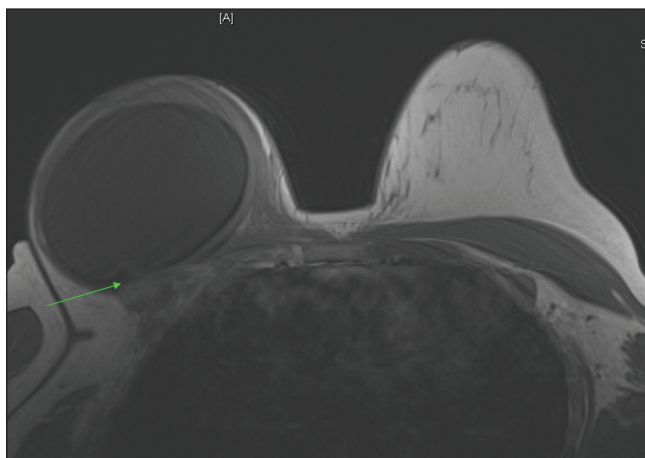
Magnetic resonance imaging demonstrating right breast saline implant with a fluid-filled level between the posterior aspect of the implant and the fibrous capsule (arrow), causing concern for noncollapsed intracapsular rupture and extracapsular rupture with associated hemorrhage
